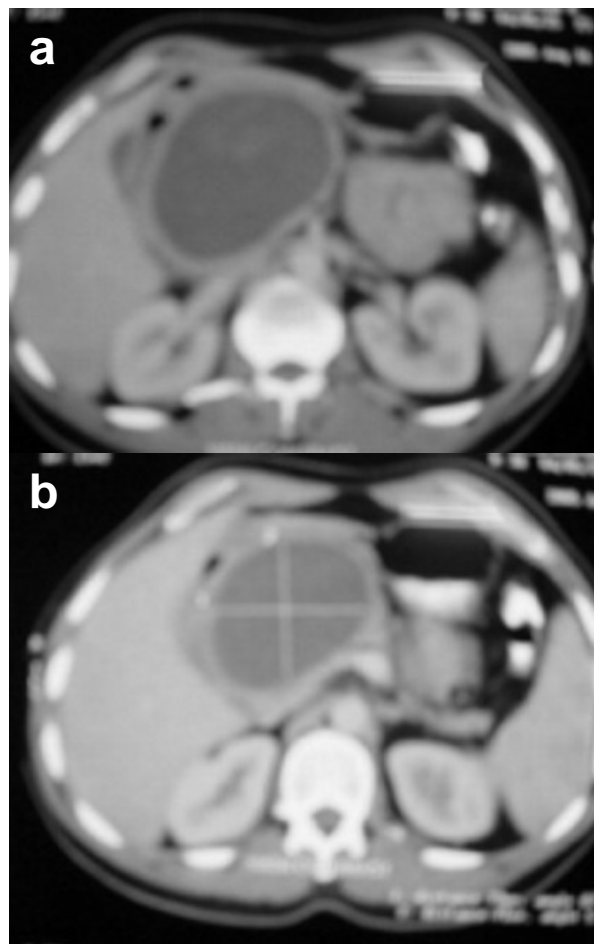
CT scan of the pancreatic mass.
